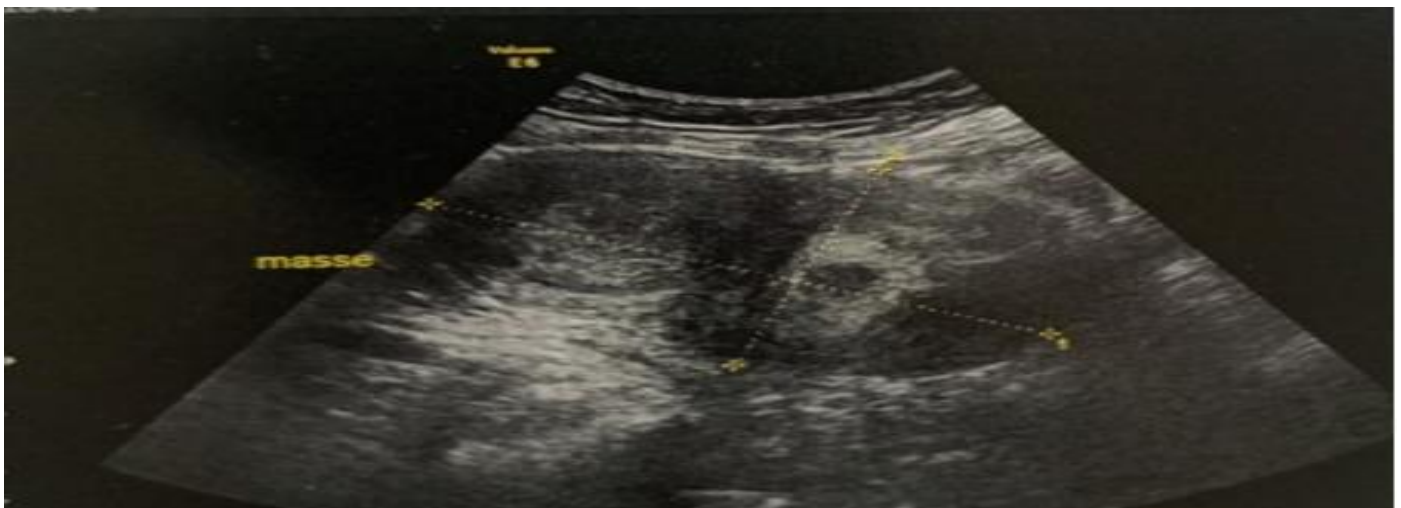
Pelvic Ultrasound Revealed a Solid-Cystic Latero-Uterine Mass
